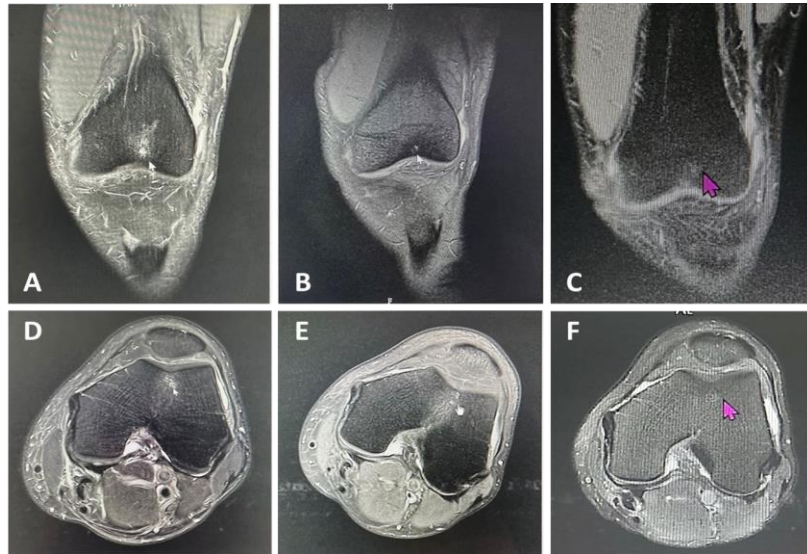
Serial T2-Weighted Magnetic Resonance Imaging (MRI) of the Left Knee Demonstrating Structural Improvements in Chondromalacia Following TELOXOME Therapy
